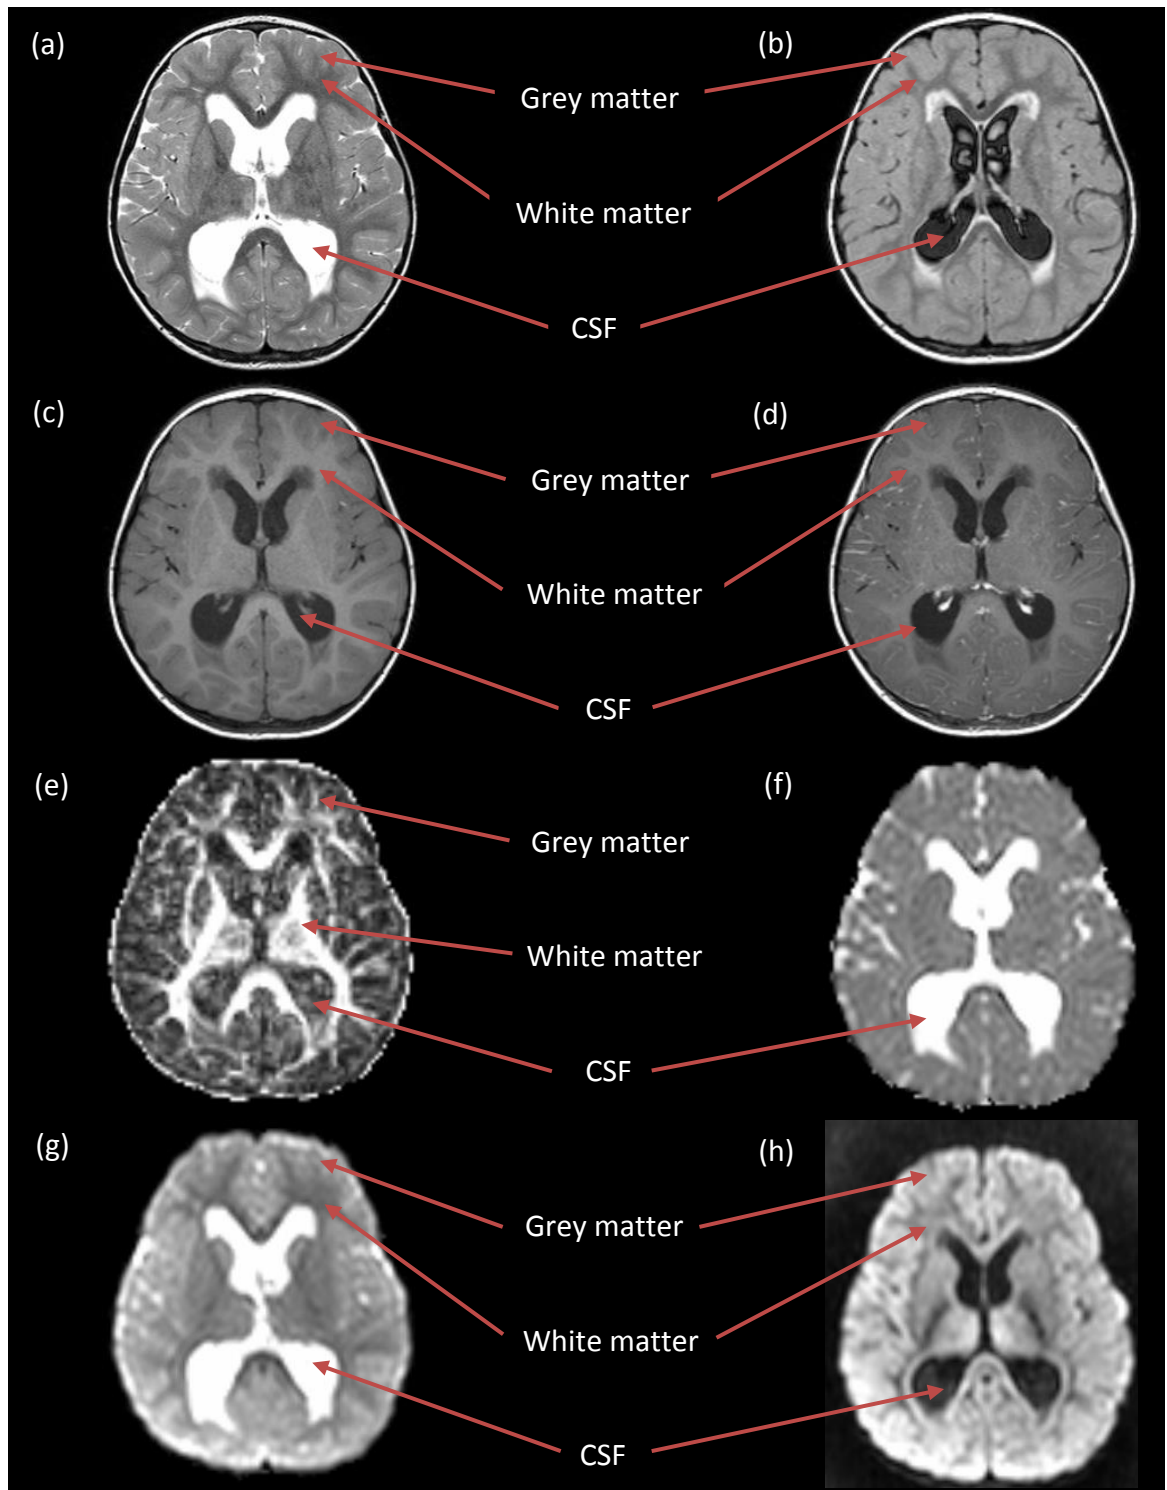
Imaging features of grey matter, white matter and CSF obtained from (a) T2, (b) FLAIR, (c) pre-contrast T1, (d) post-contrast T1, (e) FA, (f) ADC, (g) DWI at $b = 0$ and (h) DWI at $b = 1000 \text{ s/mm}^2$ (case MB719).
